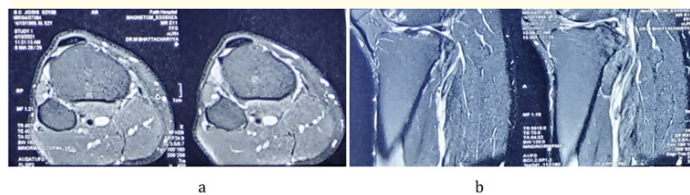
(a,b): Preoperative MRI views showing the common and deep peroneal nerves covered by cyst.
